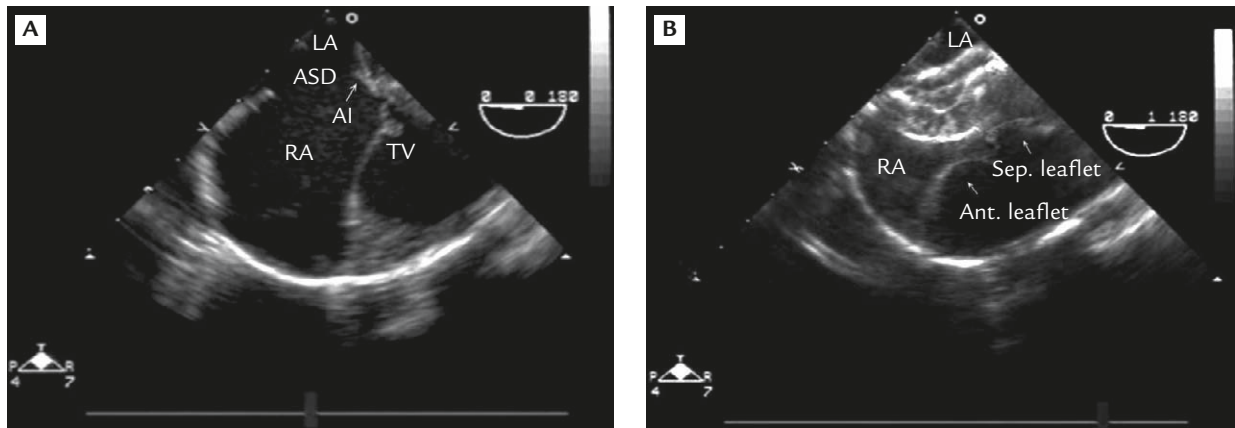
(A) Transesophageal echocardiography before Amplatzer septal occluder (ASO) implantation: apical four-chamber view shows a large secundum atrial septal defect with a limited anteroinferior rim measuring approximately 2 mm in length. (B) Although the right atrial disc of the ASO was seen touching the septal annulus of the tricuspid valve after occlusion, there was no significant tricuspid valve stenosis or insufficiency present. LA = left atrium; ASD = atrial septal defect; AI = anteroinferior rim; RA = right atrium; TV = tricuspid valve; Ant. = anterior; Sep. = septal.
